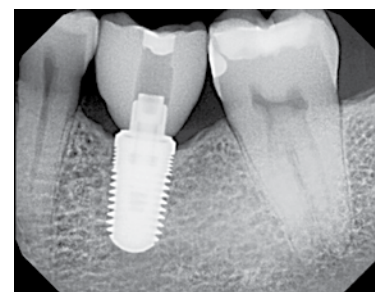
Radiograph at an 18 month recall appointment indicates that positive bone height has been maintained.
